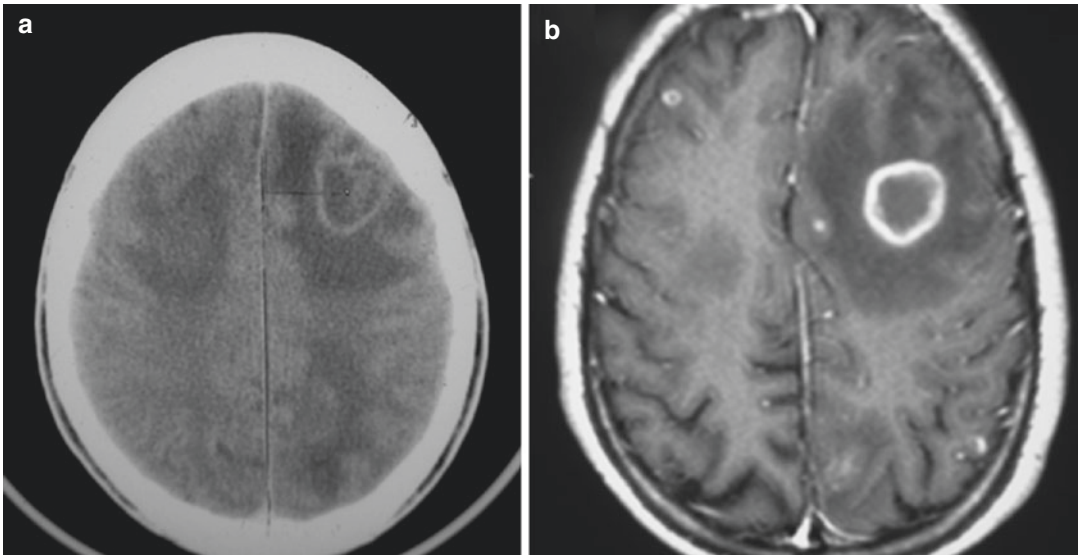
TBA. (a) Axial post-contrast CT image shows ring-enhancing lesions in *left* frontal lobe with marked peripheral edema. (b) Axial post-contrast T1-weighted
